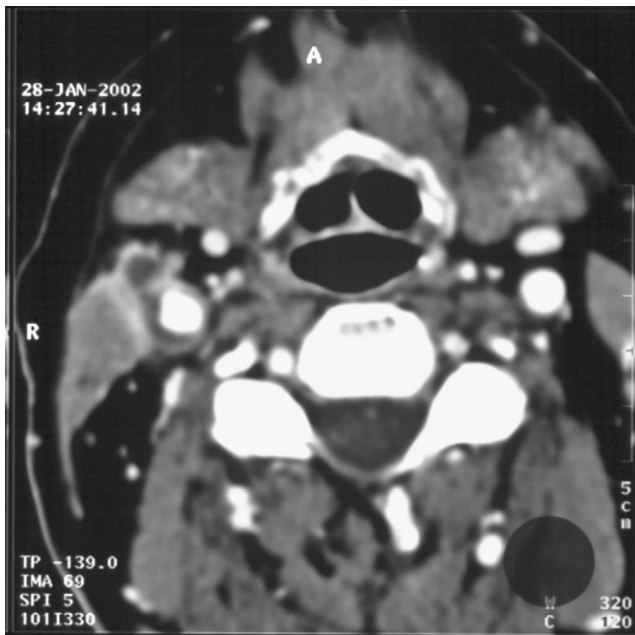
Pat. 2. Pseudoaneurysm of the left internal carotid artery detected on computed tomography (CT)-scan in a late sterile patch infection.
